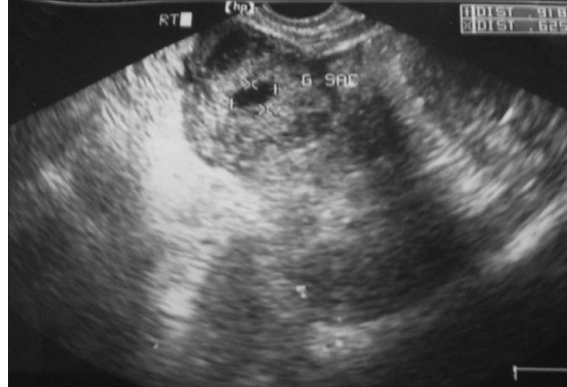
TVS Ultrasonogram showing ectopic gestation
